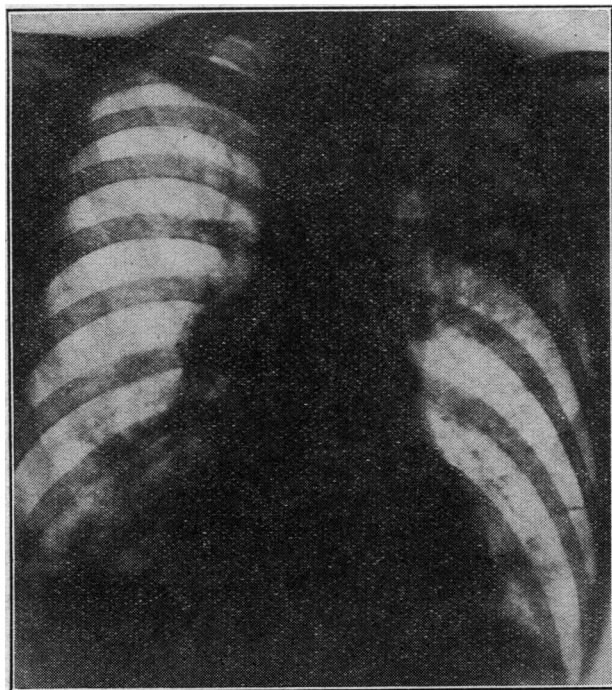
Radiograph of chest (February 19) showing opacities in left upper and mid-zones.
